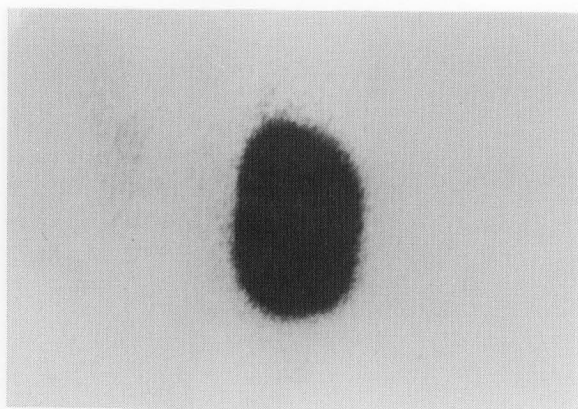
Thyroid scintigraphies of a patient with a STN which proved to be a papillary thyroid carcinoma. a) Tc-99m per technetate scan shows a hypoactive nodule (2 × 2 cm; PUS = 0) at the mid-lateral portion of the left lobe, b) TUS of the nodule was 2 on Tc-99m-TF scan.
